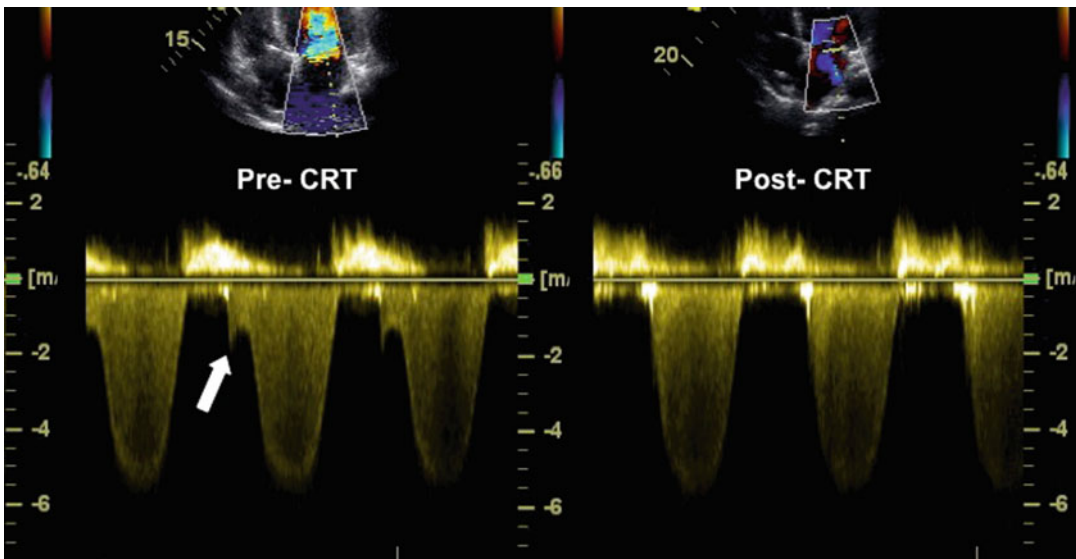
On the left panel, a continuous wave Doppler signal of a mitral regurgitation with a presystolic component can be observed that disappears with the pacemaker
